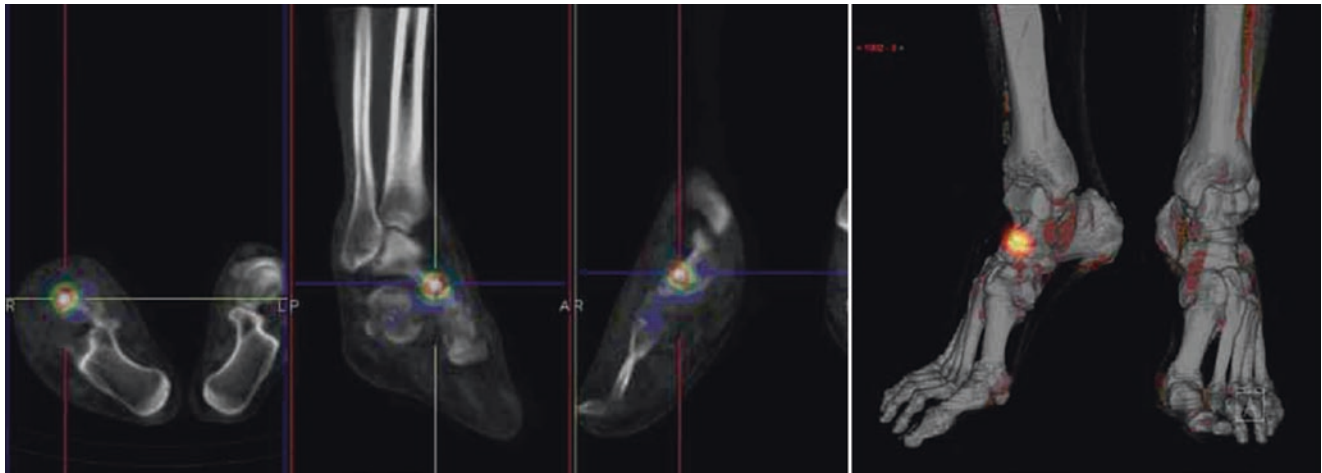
^{99m}Tc -HMPAO-WBC scintigraphy acquired 4 h post-injection in a patient with suspected infection of the right foot. Left panel: fused SPECT/CT images (transaxial, left; sagittal, middle; coronal, right) of the feet showing focal accumulation of labeled leukocytes in right talonavicular joint, consistent with septic arthritis. Right panel: 3D reconstruction of fused SPECT/CT images of lower limbs clearly
